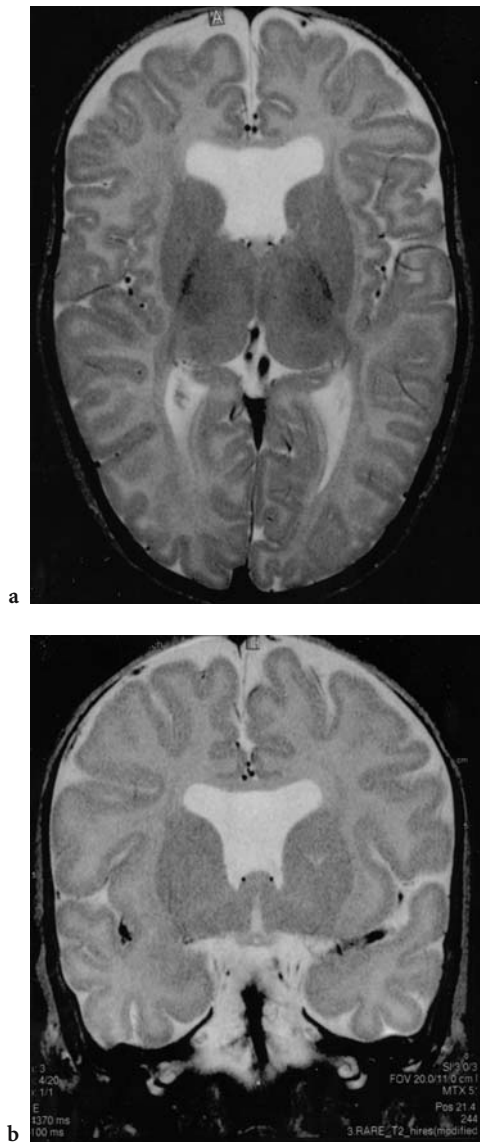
a Axial, b coronal T2-/FSE MRI of a 3-month-old-girl without visual fixation. Absent septum pellucidum and almost no identifiable optic nerves. Diagnosis: septo-optic dysplasia. Patient clinically blind at 1 year
